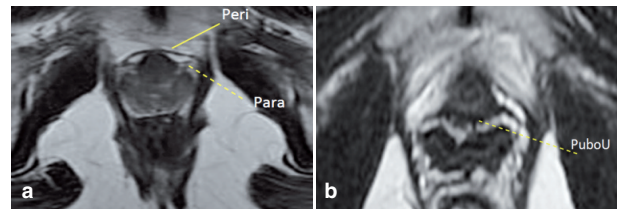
(a) Paraurethral supporting structures seen on axial T2-weighted TSE MR images: periurethral ligament (*continuous line*) and paraurethral ligament (*dotted line*); (b) pubourethral ligament (*dotted line*). Peri= periurethral ligaments; Para= paraurethral ligaments; PuboU= pubourethral ligaments.
